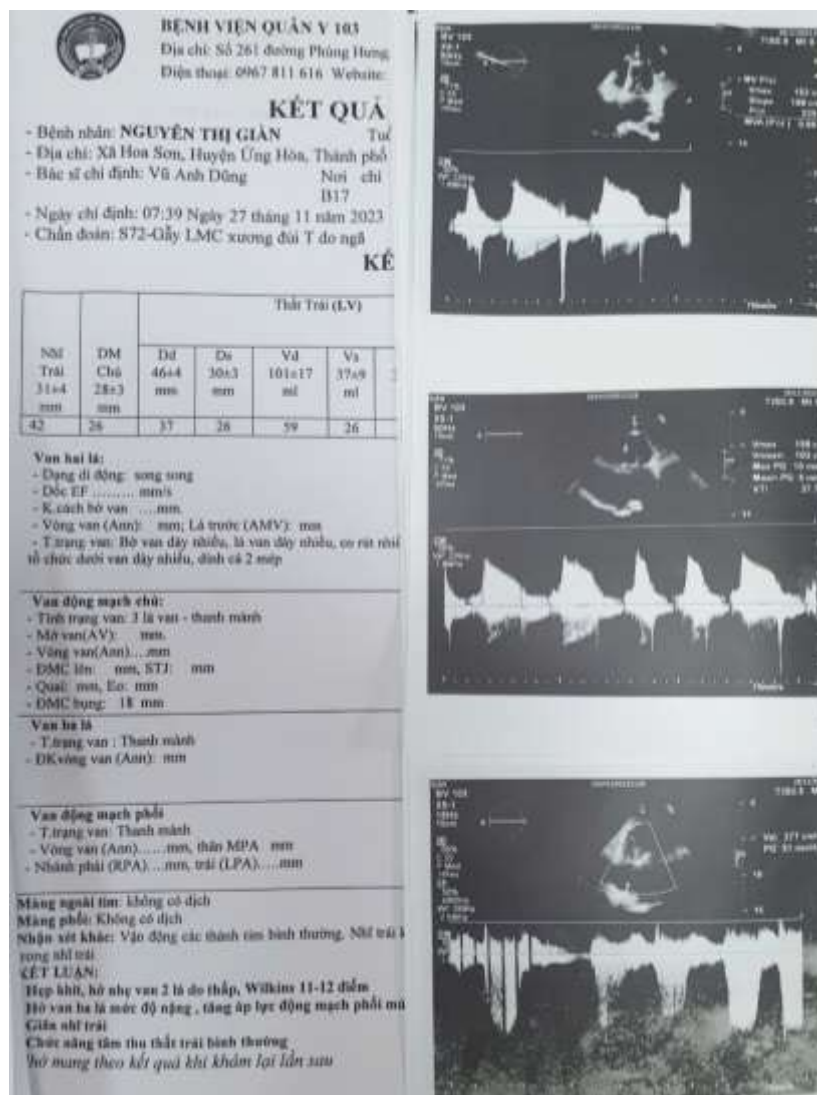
Preoperative echocardiography
